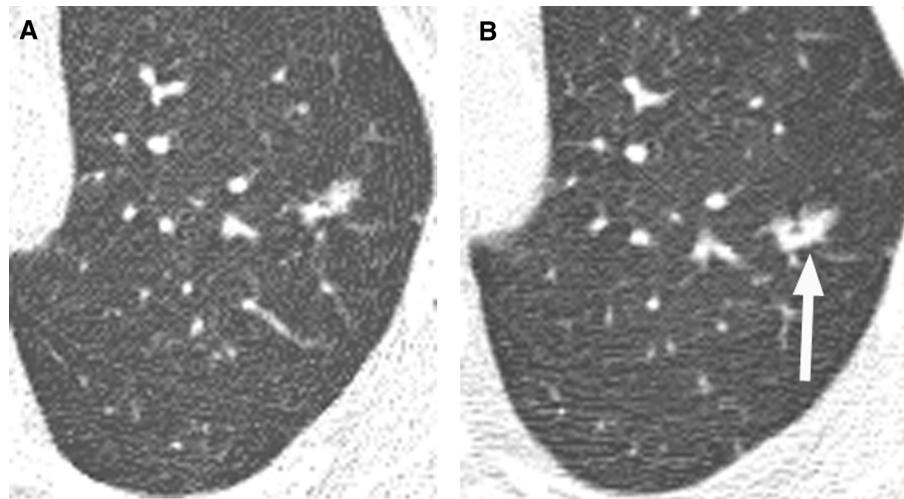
Subtle growth in adenocarcinoma. (A) A 11×5 -mm (mean, 8 mm) solid nodule is seen on screening baseline computed tomography (CT) and is characterized as Lung Reporting and Data System (LU-RADS) 3S (indeterminate; requires serial CT). (B) Follow-up screening type CT was performed at 3 months (not shown) and showed no enlargement. CT at 9 months, showing no change in the maximum dimension. Careful inspection demonstrated subtle growth posteriorly (arrow), and the nodule is now classified as LU-RADS 4C (likely malignant). Pathology demonstrated invasive adenocarcinoma with lepidic features.
